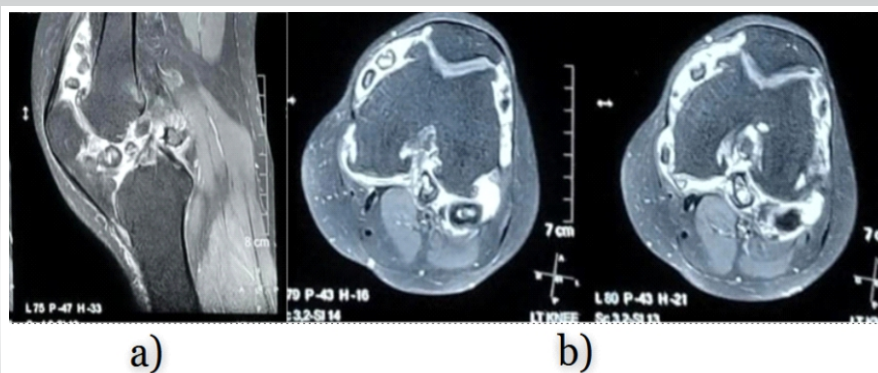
(a) Sagittal T2-weighted magnetic resonance imaging (MRI) slice depicting multiple intra-articular cartilaginous nodules of varying signal intensity within the joint effusion, (b) Axial T2-weighted MRI slices showing clustered, uniformly rounded cartilaginous nodules within the joint cavity and suprapatellar pouch.
